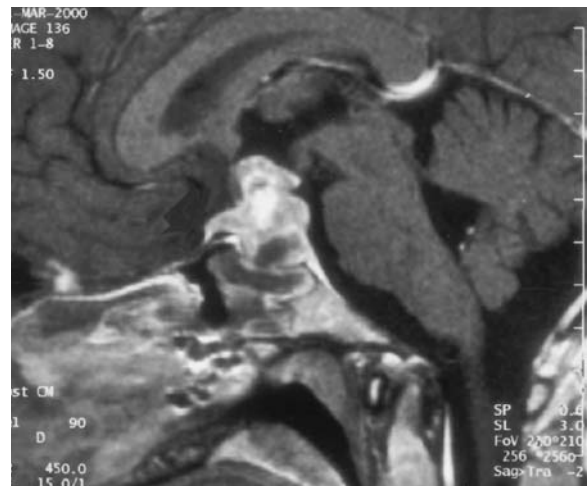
A 35-year-old woman with acute vision loss, predominantly of the right eye, and a history of breast carcinoma. Diagnosis: intra- and suprasellar metastasis. MRI: a Axial T2-weighted FLAIR sequence showing edema of the chiasm and both optic tracts. b Coronal, T1-weighted, contrast-enhanced view demonstrating tumor infiltration of the chiasm, confirmed during neurosurgery, where dissection of the optic fibers was impossible. c Paramedian sagittal, T1-weighted, contrast-enhanced view with hypothalamic infiltration, identified by flattening of the floor of the third ventricle. Note the loss of differentiation of the obviously infiltrated pituitary stalk and gland, dural infiltration of the sphenoid plane, and mucous filling of the sphenoid sinus
